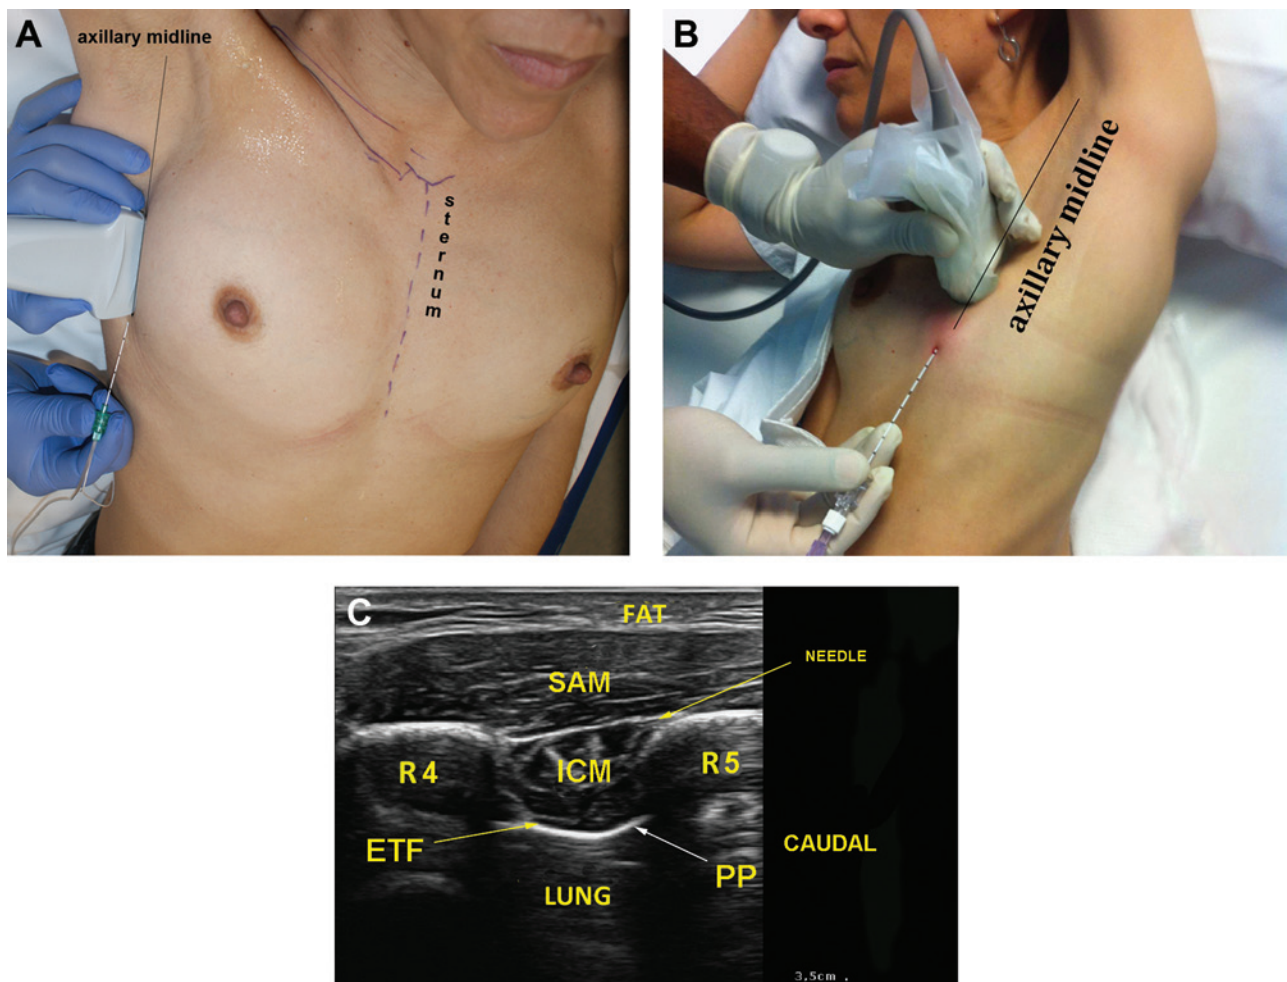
The same 38-year-old woman (shown in Figure 1) also received a serratus intercostal fascial block (SIFB) ultrasound-guided block technique prior to mastectomy. (A, B) Ultrasound probe positioning and needle insertion along the axillary midline. (C) Ultrasound image of the lateral thoracic wall showing the serratus anterior muscle (SAM), rib (R), endotherothoracic fascia (ETF), intercostal muscle (ICM), fat (FAT), and parietal pleura (PP, shown with white arrow). The needle insertion is shown with a yellow arrow.
